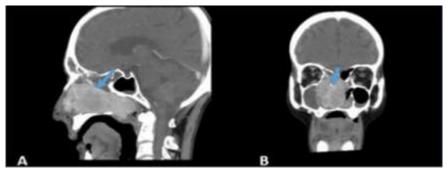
CT scan-Large well defined heterogeneously enhancing mass in the right nasal cavity
